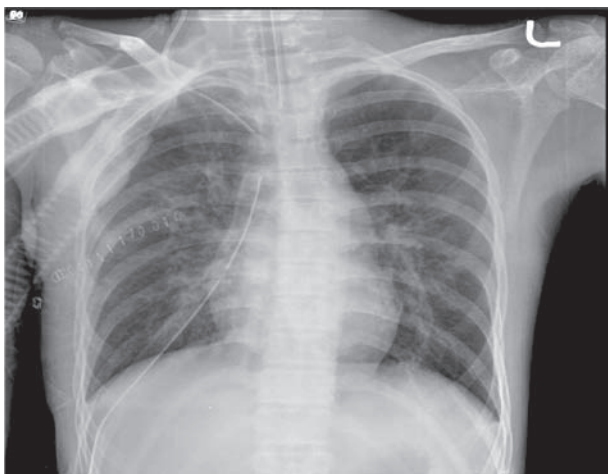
Chest x-ray after removal of ECMO.
